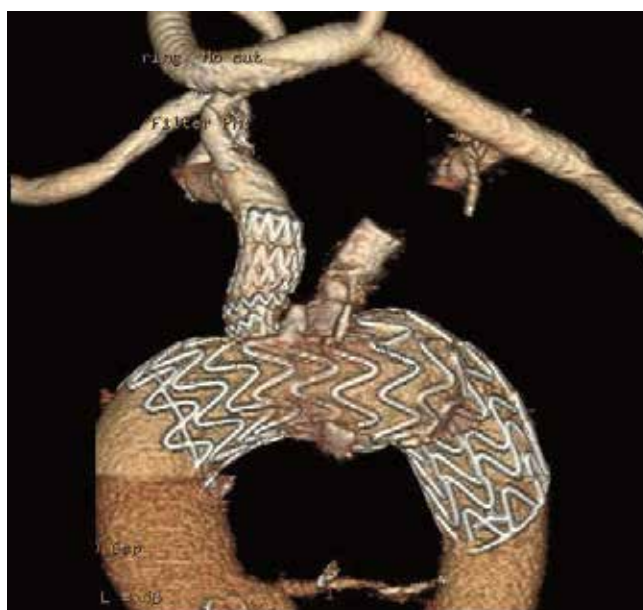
Follow-up CT angiogram at 30 days, 3-D reconstruction of the GORE® TAG® Thoracic Aortic Single Branch Endoprosthesis.
